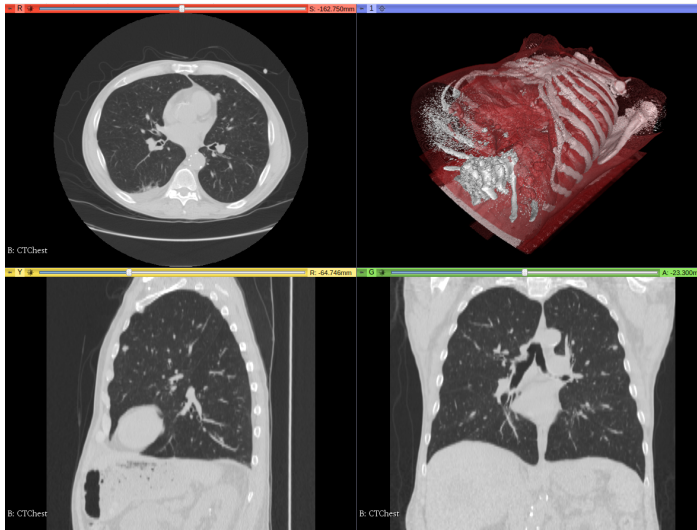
Chest CT from 3D Slicer's sample data.
